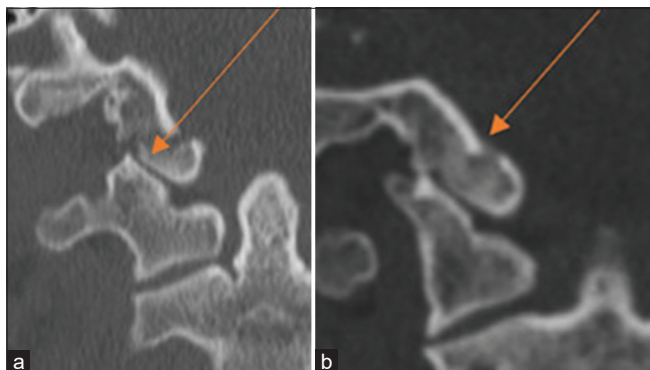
(a) A 29-year-old male with right Type I occipital condyle fracture. (b) One-month interval CT cervical spine – a 29-year-old male with right Type I occipital condyle fracture with evidence of nonsurgical fusion.
